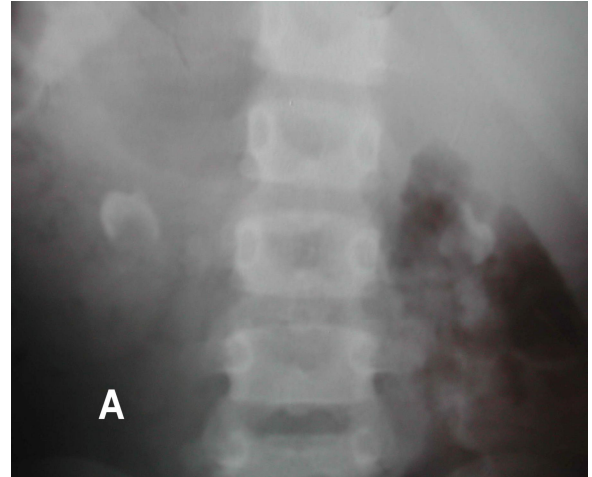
A, B, C. The appearance of the x-ray and stones cases in the second patient.
